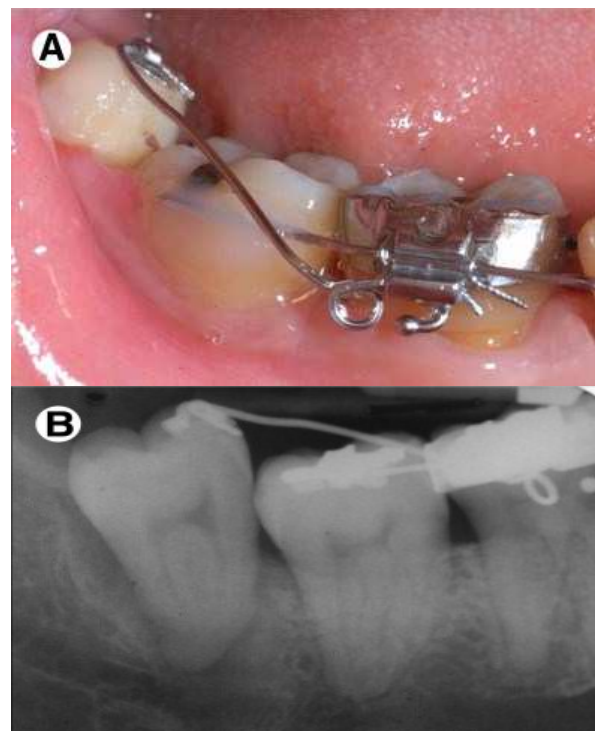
A deeply impacted third molar of the right mandible (reproduced from Alessandri et al. [11] with permission from Elsevier); (A). (A). After orthodontic extrusion of the tooth (reproduced from Alessandri et al. [11] with permission from Elsevier); (B). (B). Radiographic view after orthodontic extrusion of the tooth (reproduced from Alessandri et al. [11] with permission from Elsevier)
